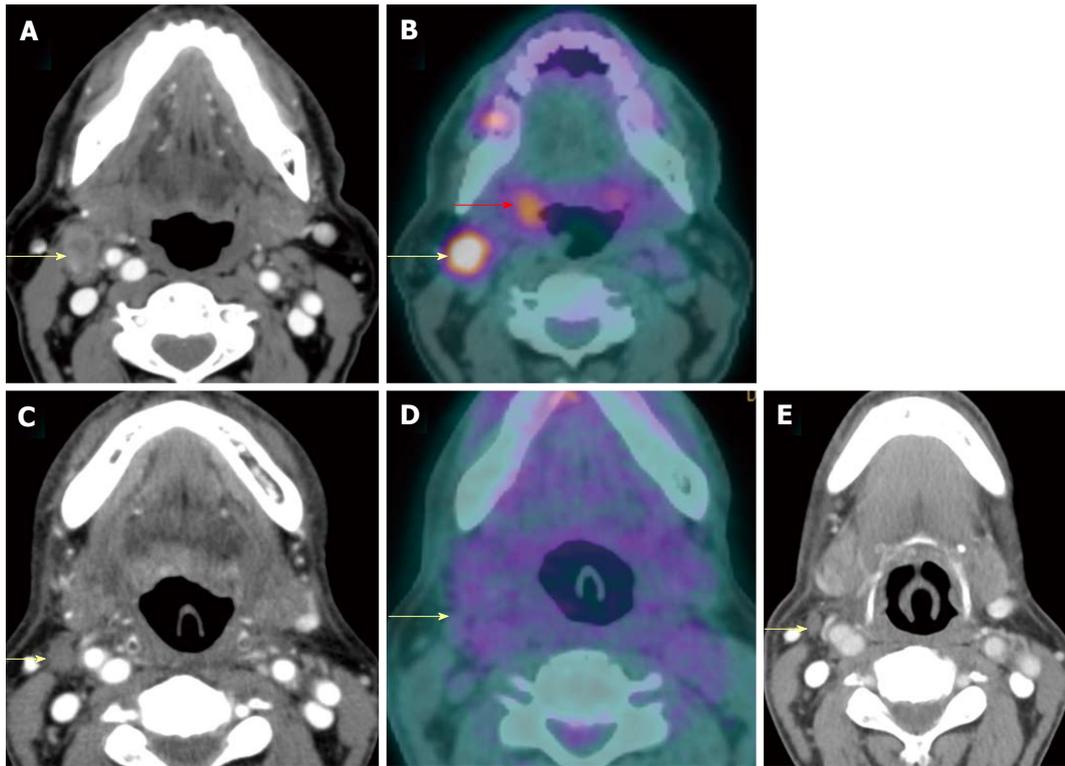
Complete response of a metastatic lymph node. A T2N2bM0 right palatine tonsil squamous cell carcinoma (red arrow) and right level II a metastatic lymph node (yellow arrows) were seen on both contrast-enhanced computed tomography (CT) (A) and positron emission tomography/CT (PET/CT) (B). After chemoradiation, the node was smaller on contrast-enhanced CT at 6 wk (C) and hypometabolic on PET/CT at 4 mo (D), representing complete response to treatment. Negative physical examination and PET/CT at 1 year (E) confirmed true negative result of the PET/CT performed at 4 mo.
